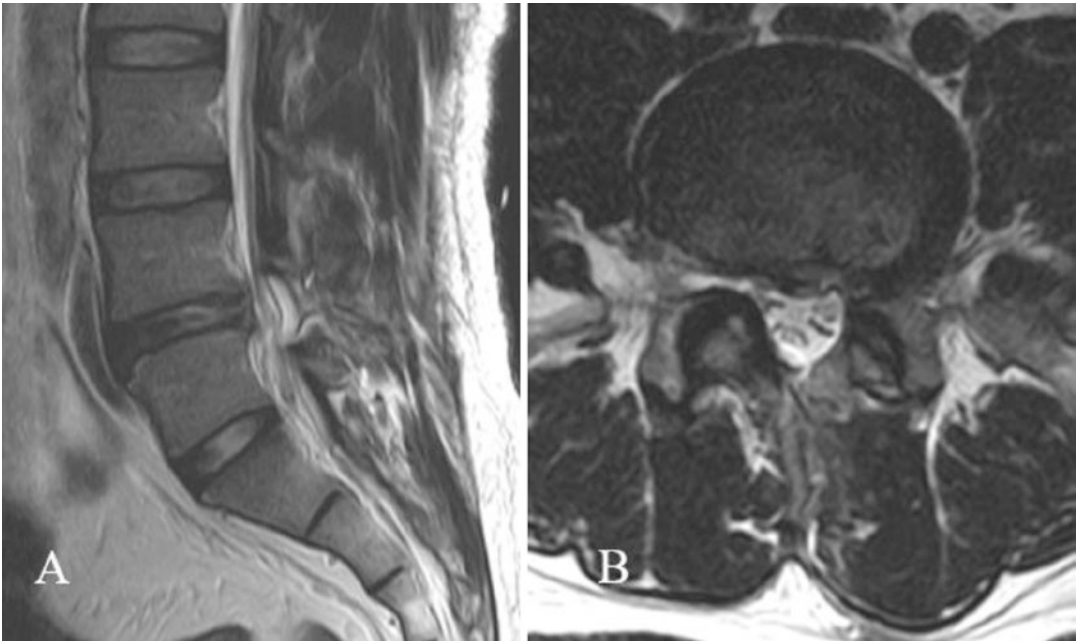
(a) Postoperative MRI shows decompressed state at L4/5 (sagittal view). (b) Axial view shows well-decompressed lesion site at L4/5 intervertebral disc level. In addition, postoperative paraspinal muscle change is slight
